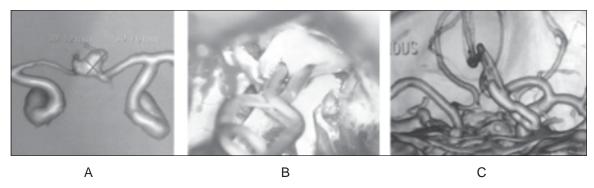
CT angiogram shows ACOM aneurysm (A), Peroperative clipping of ACOM aneurysm (B) & Post clip angiogram shows no residual aneurysm (C).
